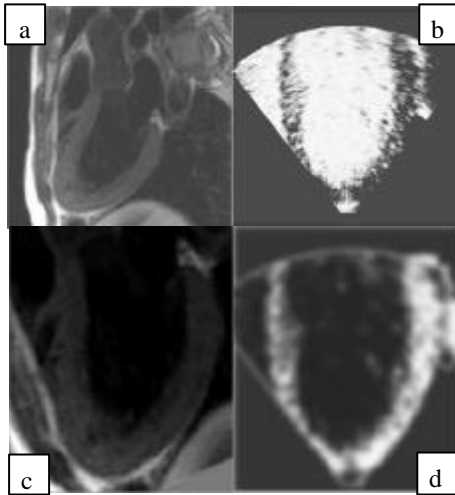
MRI model slice (a) and corresponding echographic image (b). Aligned versions of this images have been obtained by registration (c,d)
